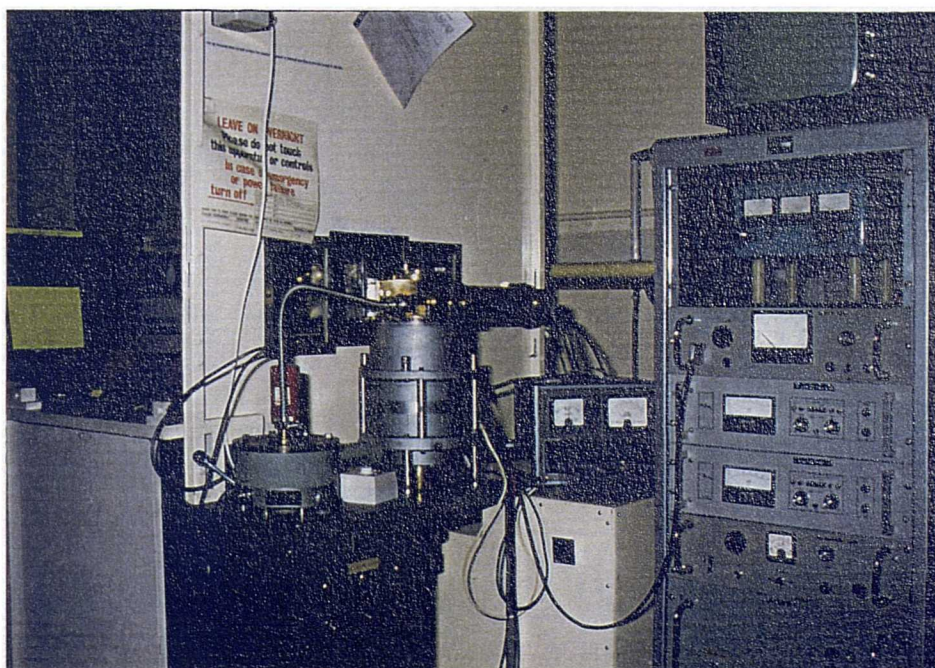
Microfocal X-ray unit, showing the X-ray generator in the foreground, a protective screen with window behind which the mounted tooth sections are placed and in the distance the yellow mounting card where the radiographic film is placed.
